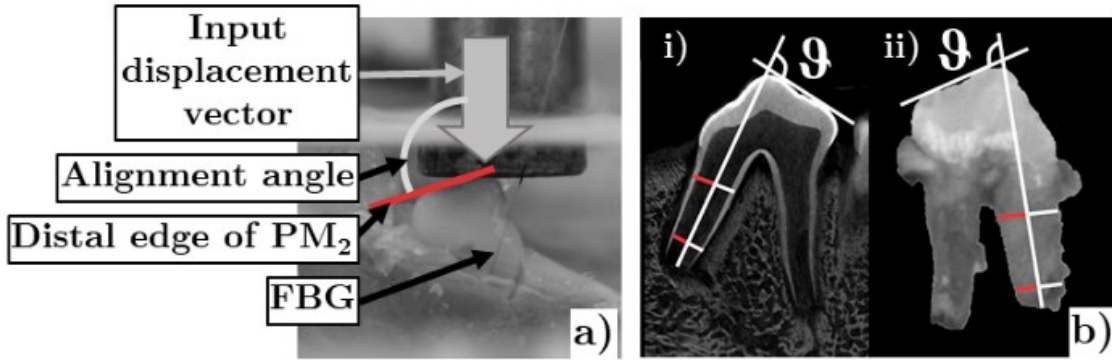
(a) View of the alignment of an RPM2 submerged in 0.9% NaCl with the approximate alignment angle of  $102^\circ$ . (b) Representation of measurements from the (i)  $\mu$ CT scans on an LPM2 and (ii) camera images of an RPM2, to determine the angle ( $\theta$ ) between the distal edge of the crown and the approximate axis of the mesial root.
